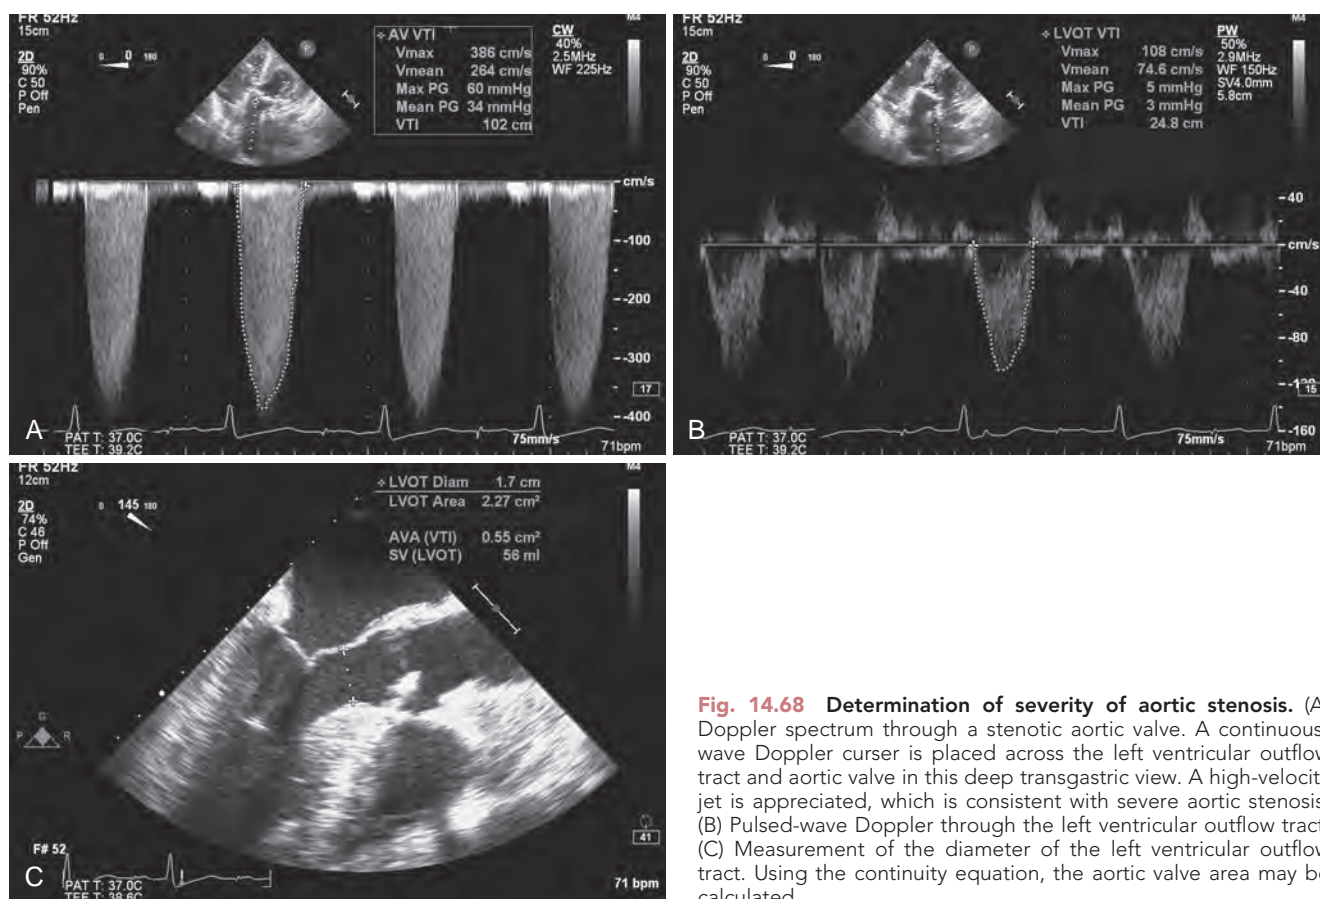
Determination of severity of aortic stenosis. (A) Doppler spectrum through a stenotic aortic valve. A continuous-wave Doppler cursor is placed across the left ventricular outflow tract and aortic valve in this deep transgastric view. A high-velocity jet is appreciated, which is consistent with severe aortic stenosis. (B) Pulsed-wave Doppler through the left ventricular outflow tract. (C) Measurement of the diameter of the left ventricular outflow tract. Using the continuity equation, the aortic valve area may be calculated.
